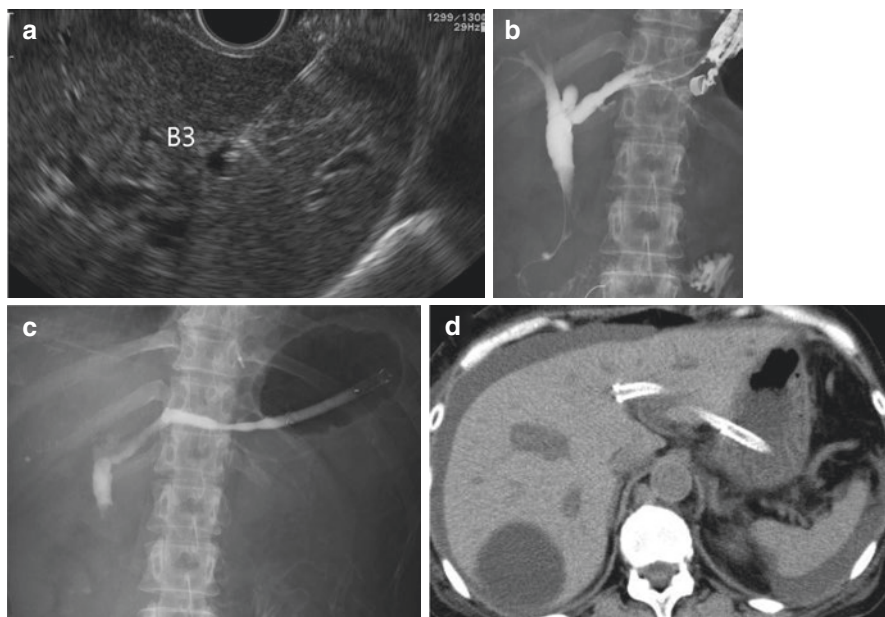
EUS-HGS technique. (a) Segment 3 (B3) should be initially selected as puncture site. (b) Guide wire is inserted up to common bile duct, and then obstruction site and left bile duct are confirmed using contrast. (c) After deployment of metallic stent. (d) CT image
